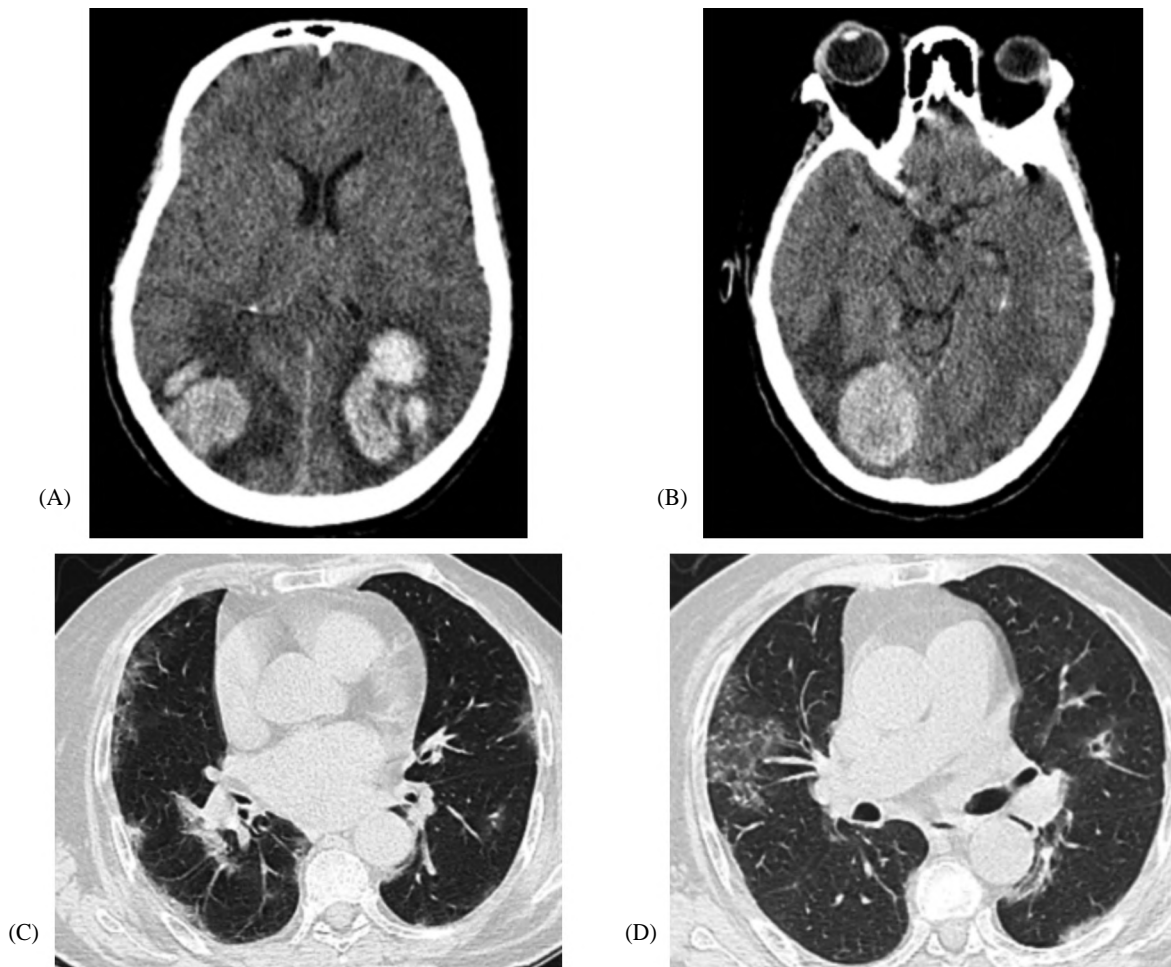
(a,b) Axial CT brain in 55 years old female patient, post COVID 19, presented by disturbed conscious level, showing multiple bilateral cerebral hemorrhagic infarcts. (C,D) Axial CT chest lung window, CT severity score 10, showing bilateral patchy faint ground glass opacities with crazy paving at the right side.
